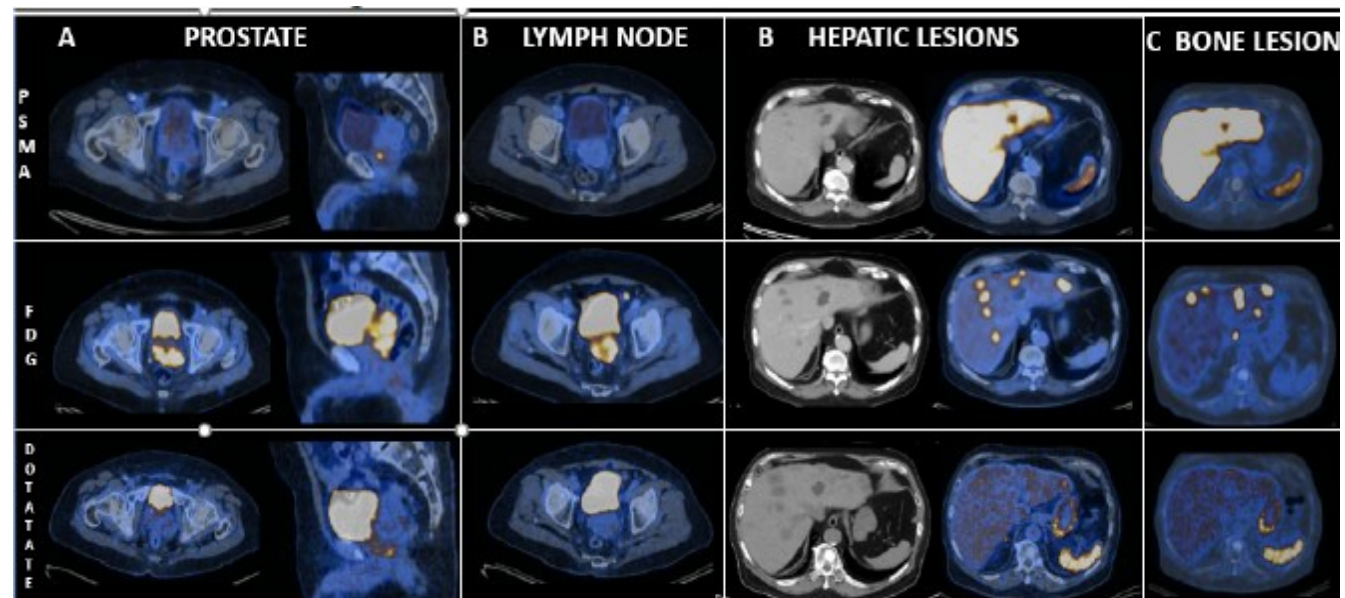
Comparison of fused F-18 PSMA PET/CT, F-18 FDG PET/CT and Ga-68 Dotatate PET/CT images.
